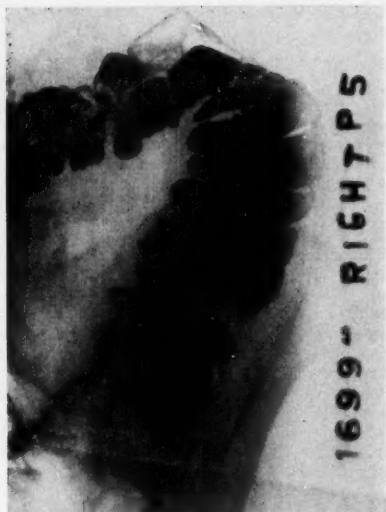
N. D. a 42 year old white female with alternating diarrhea and constipation, and abdominal cramps for four years' duration. The first examination (a) showed an irregularity at the ileocecal region. Since the ileocecal entrance is never at the inferior tip of the cecum, a re-examination was undertaken. In the second examination (b), the large filling defect of the cecum is better outlined. The only feature that differentiated this defect from a malignant defect was the associated narrowing of the terminal ileum with a large ulcer crater protruding from its superior aspect. At operation, a large hyperplastic inflammatory mass was found, with ulcerations and fistulous tract formation. The similarity of the Roentgen features to tuberculosis is noteworthy.
